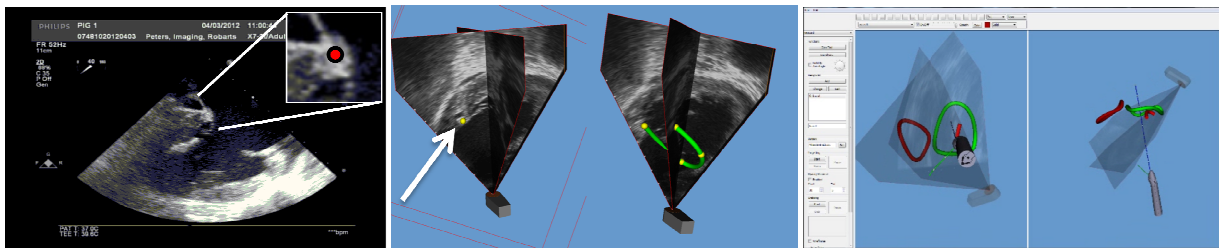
2D echocardiography image with mitral valve hinge point (left), manual annulus identification and 3D representation via spline interpolation (mid) and the mixed-reality guidance interface described by Moore et al. (right).
